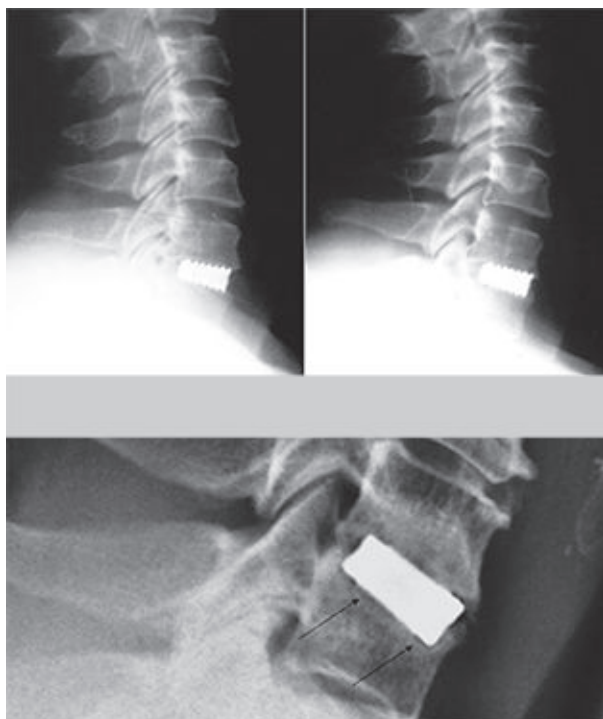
(A) Postoperative lateral radiograph of a patient with C6-7 disc herniation grafting by a 8mm cage. (B) One-year follow-up radiograph revealed maintenance of disc height and successful fusion. (C) A radiolucent gap can be seen in both cases around the cage (arrows).
